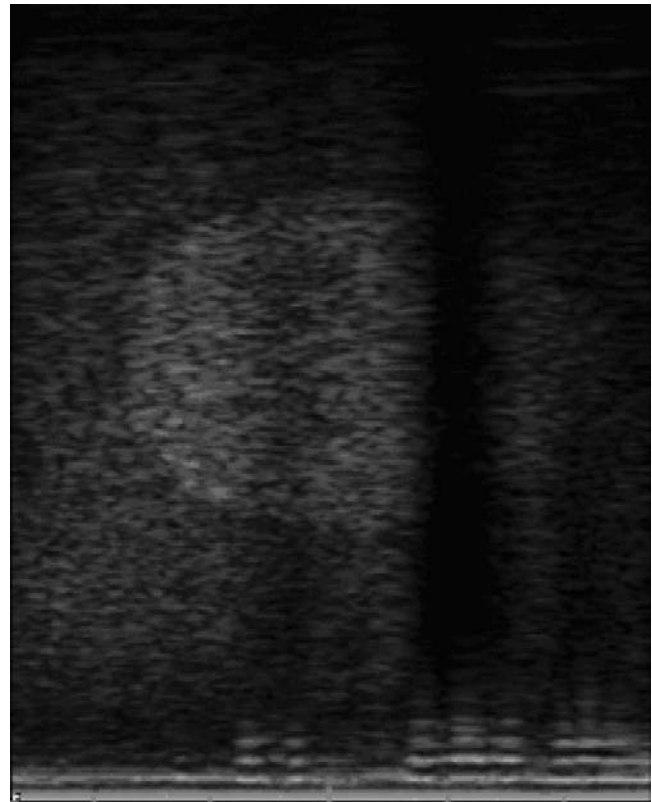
Artifact caused by poor contact between the ultrasound probe and the scan surface. In this case, the source of poor contact is insufficient coupling gel, leaving an air gap between the probe and scan surface.
